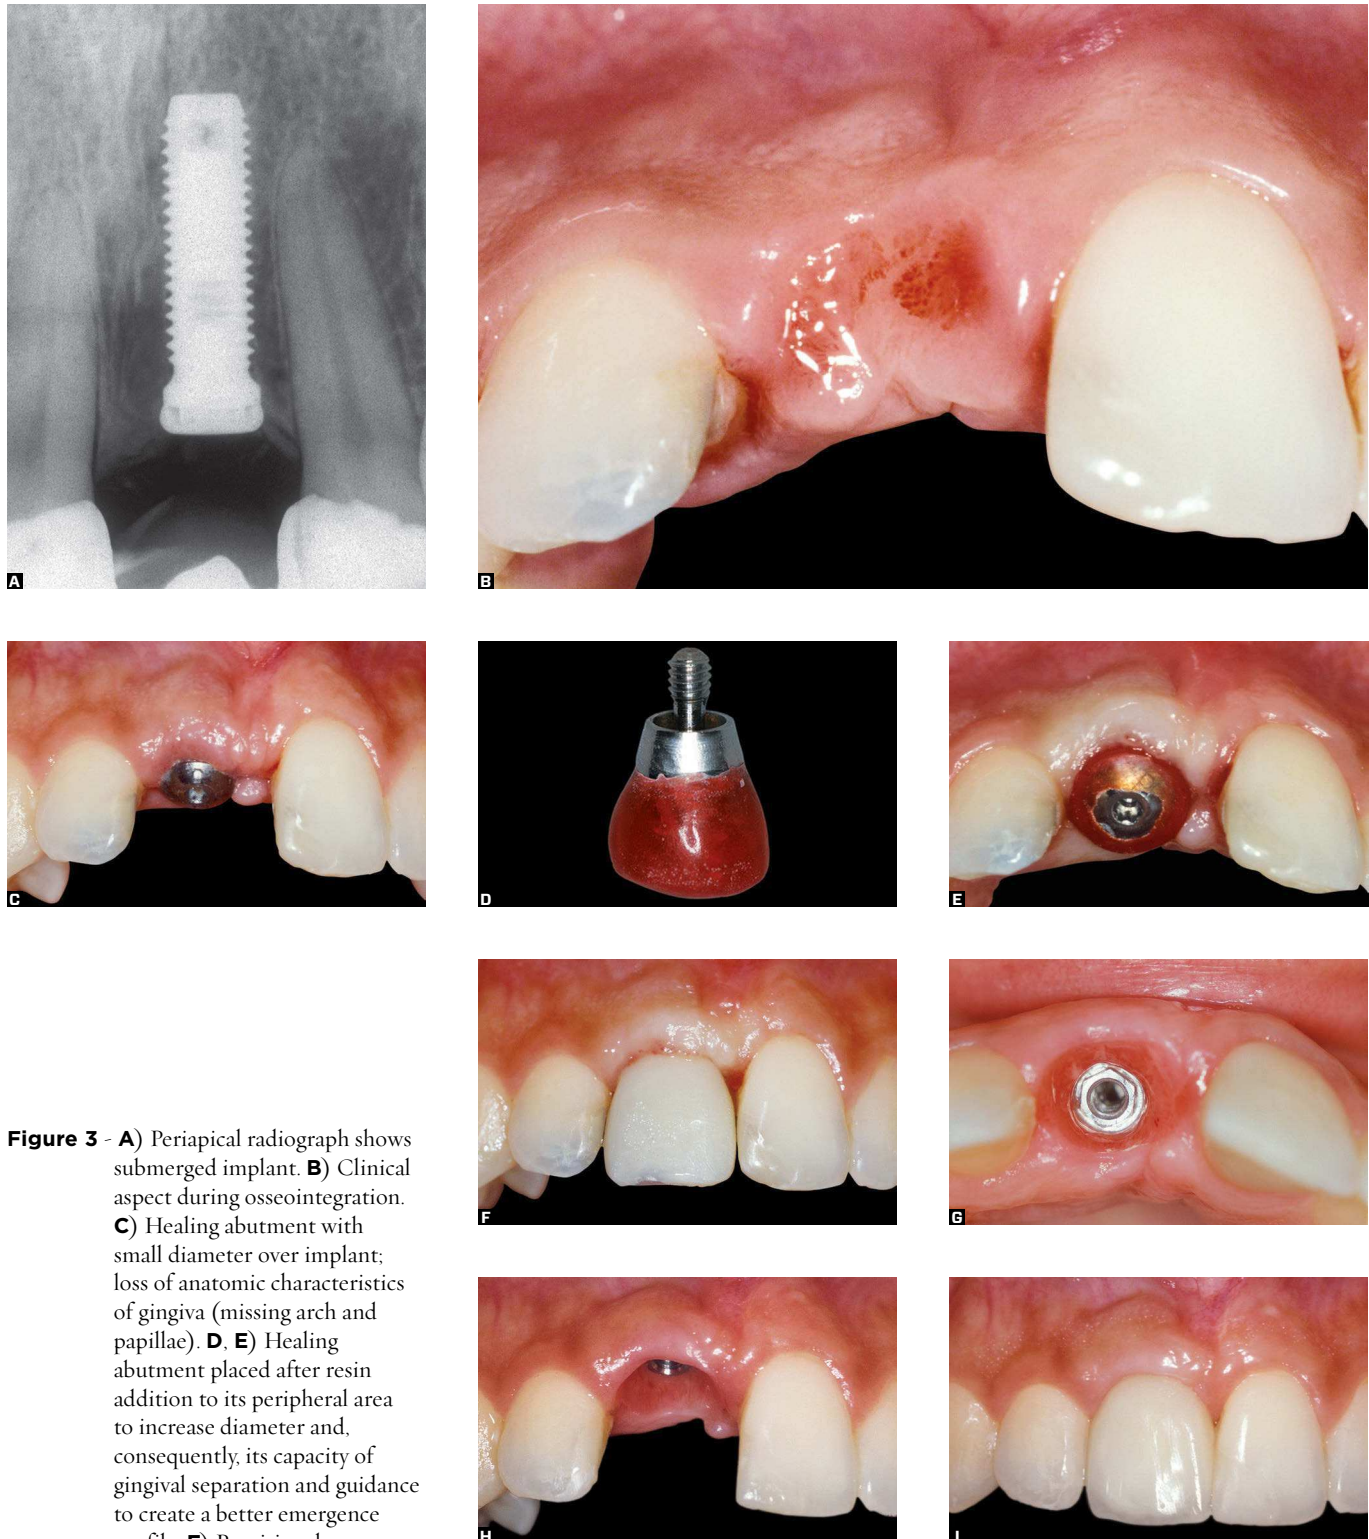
A) Periapical radiograph shows submerged implant. B) Clinical aspect during osseointegration. C) Healing abutment with small diameter over implant; loss of anatomic characteristics of gingiva (missing arch and papillae). D, E) Healing abutment placed after resin addition to its peripheral area to increase diameter and, consequently, its capacity of gingival separation and guidance to create a better emergence profile. F) Provisional crown replacing healing abutment to refine and complete gingival guidance for esthetic results. G) Peri-implant tissue after final recontouring. H) Buccal view shows adequate gingival contour and papillae. I) Ceramic crown after finishing.
